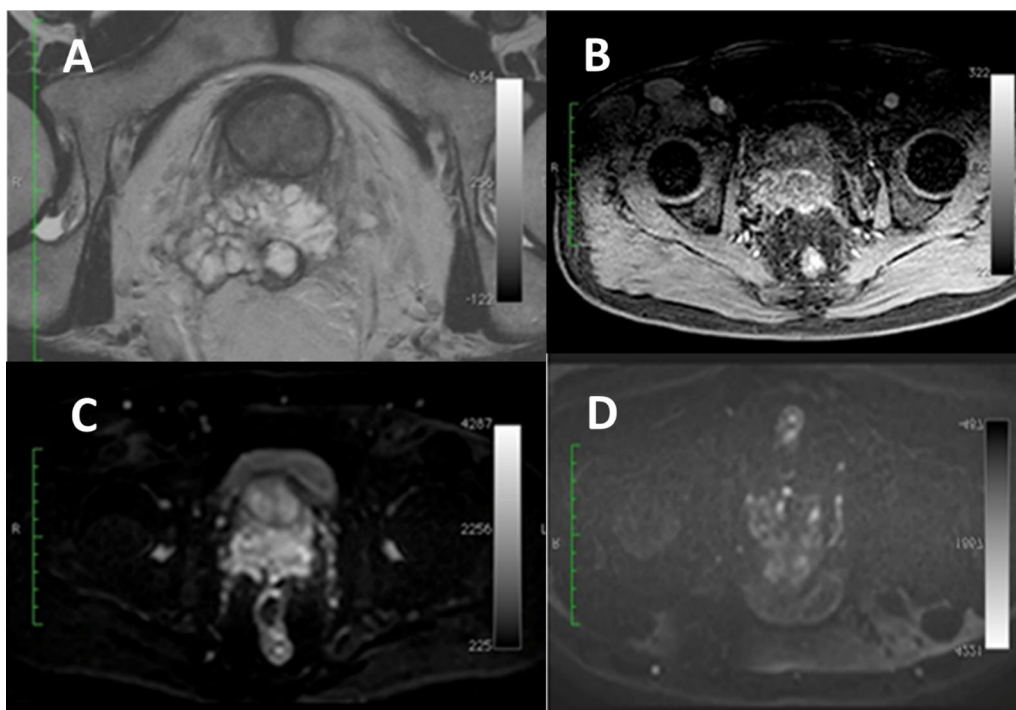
A Axial T2 sequence demonstrating a homogeneous moderate T2 hyperintense mass in the peripheral zone (PZ) extending into the posterior periprostatic tissue. B Axial post-contrast T1 THRIVE sequence of the prostate demonstrating inhomogeneous enhancement of the lesion, with intense early enhancement in the septa and no enhancement in the mucoid matrix. C–D Axial high-b value DWI sequence and the respective ADC map demonstrating a moderately hyperintense prostatic mass on DWI with corresponding markedly hyperintense signal on ADC, findings consistent with T2 shine-through effect [10]
